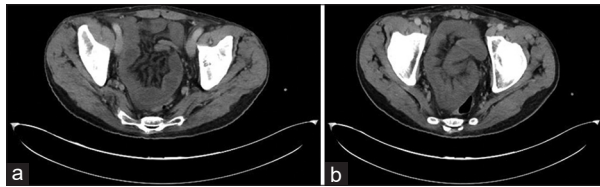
(a and b) Axial abdominal computed tomography scan reveals dilated small bowel loops with no signs of ischemia or infarction
